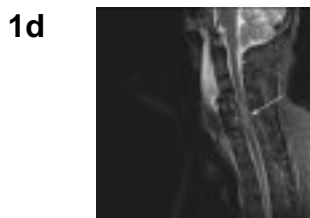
(Magnetic Resonance Imaging): Post surgical MRI of the same patient showing plate and screw fixation of C4-C6 vertebral bodies. There is expansion and high signal of the cord from the mid-C4 to mid-C7 level (arrow). This most likely represents an intramedullary contusion injury.
